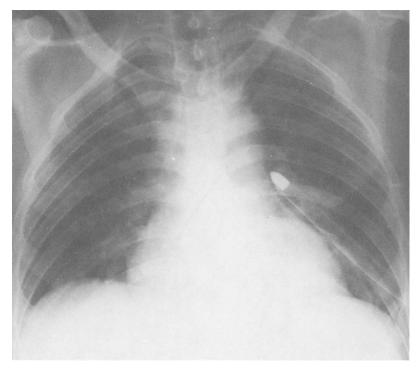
The initial chest radiograph shows a bullet-shaped density overlying the tip of the left chest tube.
